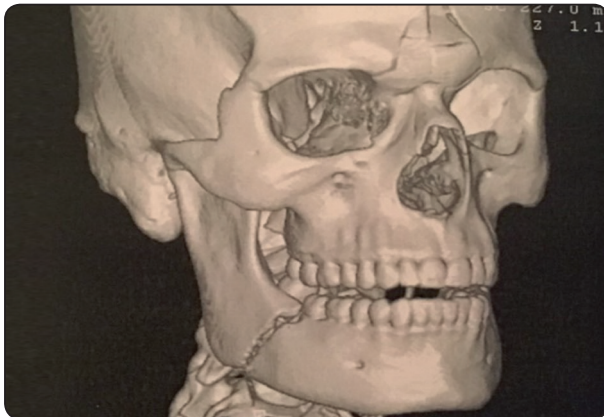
3d CT scan showing unilateral mandibular angle fracture with less than 5mm displacement between fractured segments.
